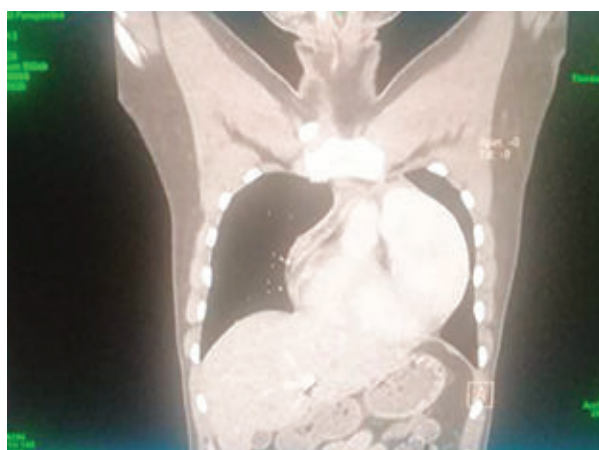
Preoperative CT scan of the chest
